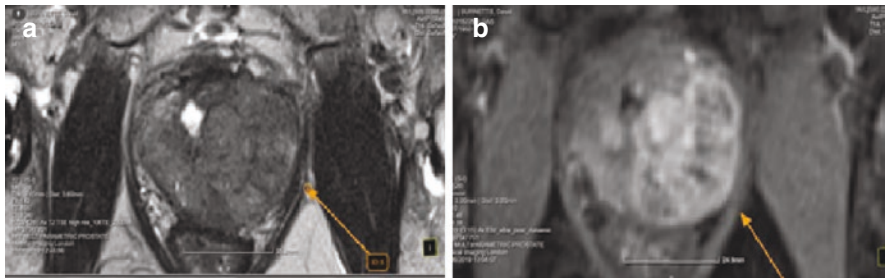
Prostatic TB: MRI prostate Coronal T2 (Image a) and contrast enhanced coronal images (Image b) showing intense contrast enhancement bilaterally but predominantly in the left half of the gland (yellow arrows). *Image courtesy Dr Uday Patel, Consultant Radiologist, St George's Hospital NHS Trust, London, UK*
